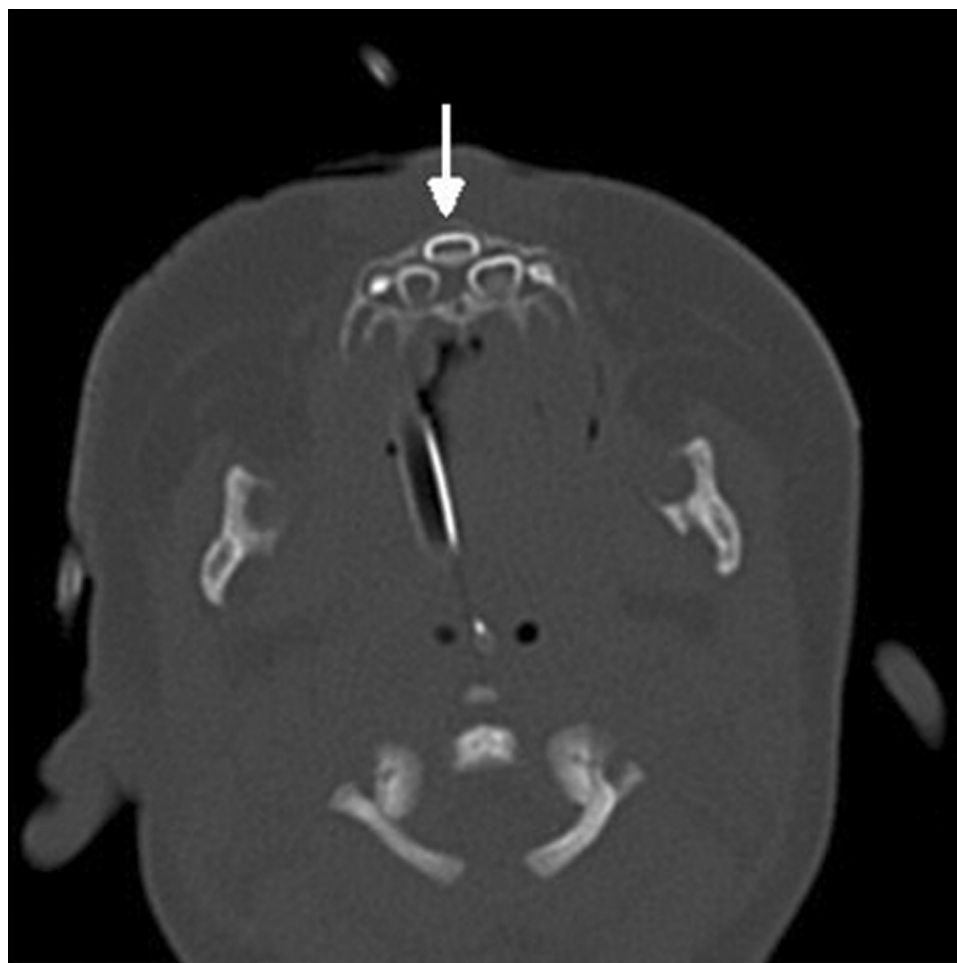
CT scan showing central frontal mega-incisor tooth (arrow).
